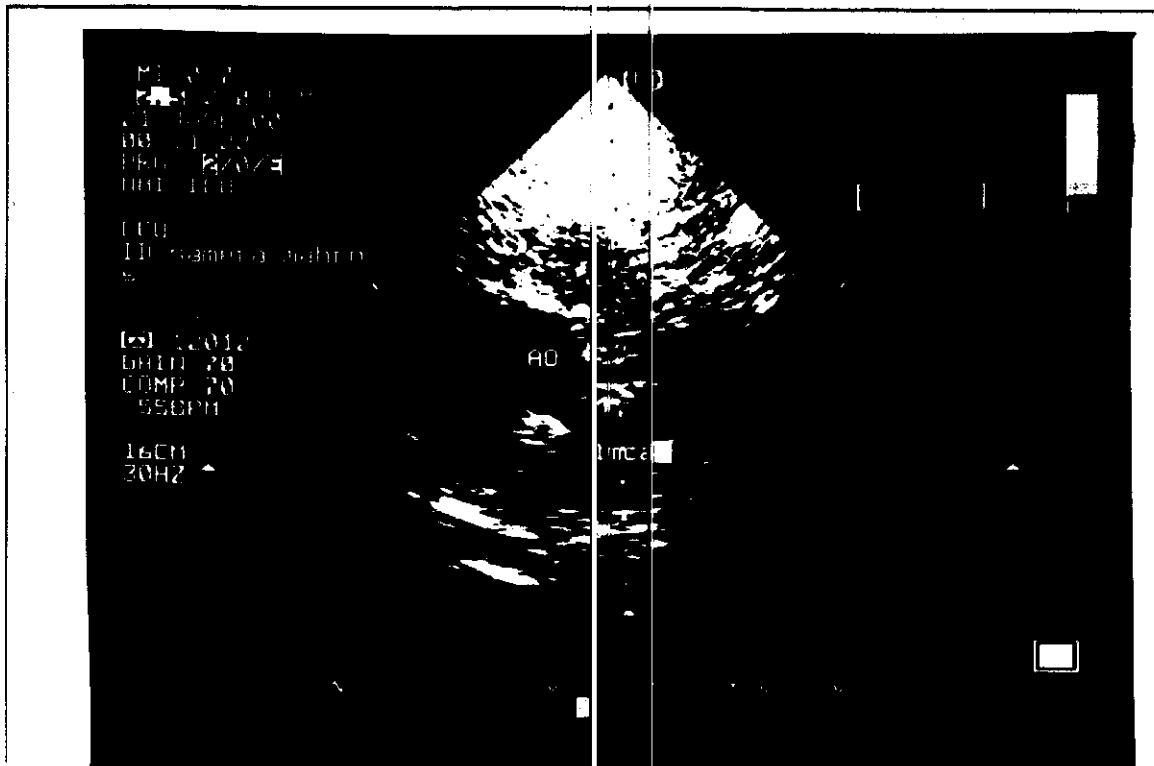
Fig (II) Transthoracic echocardiogram (parasternal non-standard short axis view) from patient without LM/CAD showing normal left main coronary artery arising from the left coronary sinus (patient No.8)
